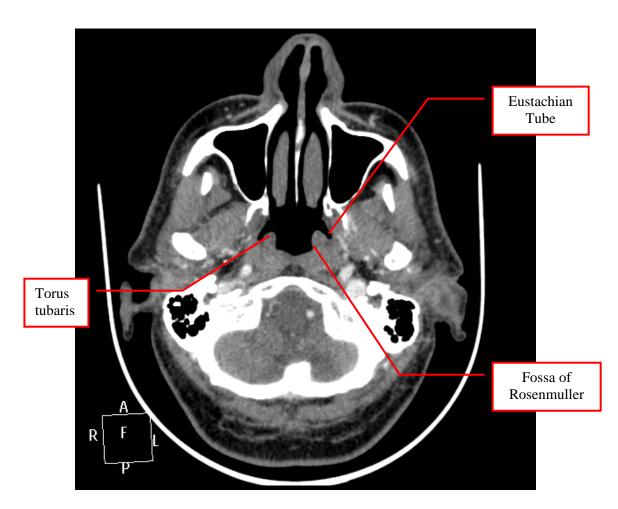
CT- Axial cut through a normal nasopharynx.
